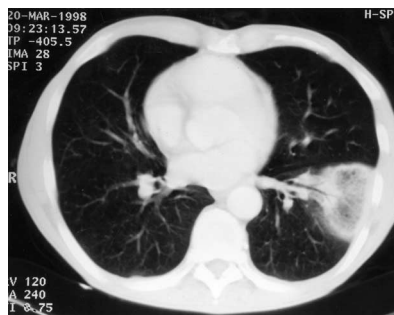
Computed tomography appearance of lesion, showing a cavitating septic pulmonary infarct.
